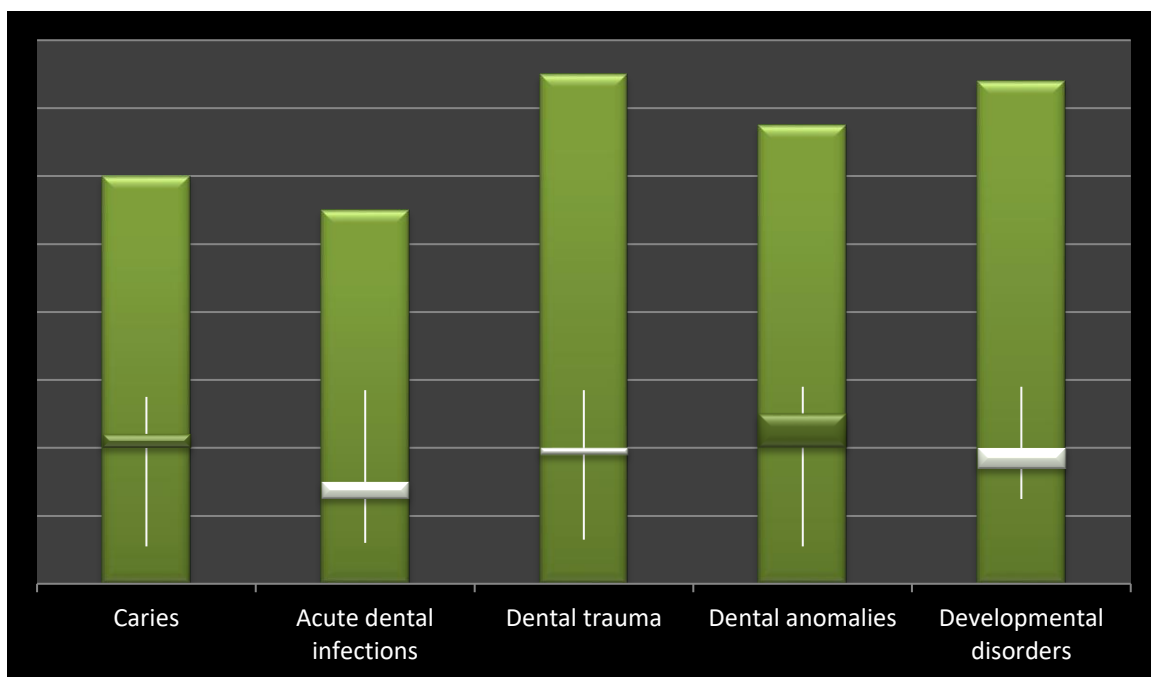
Box and whisker plot showing the analysis of evaluation of different clinical conditions by CBCT in paediatric patients
